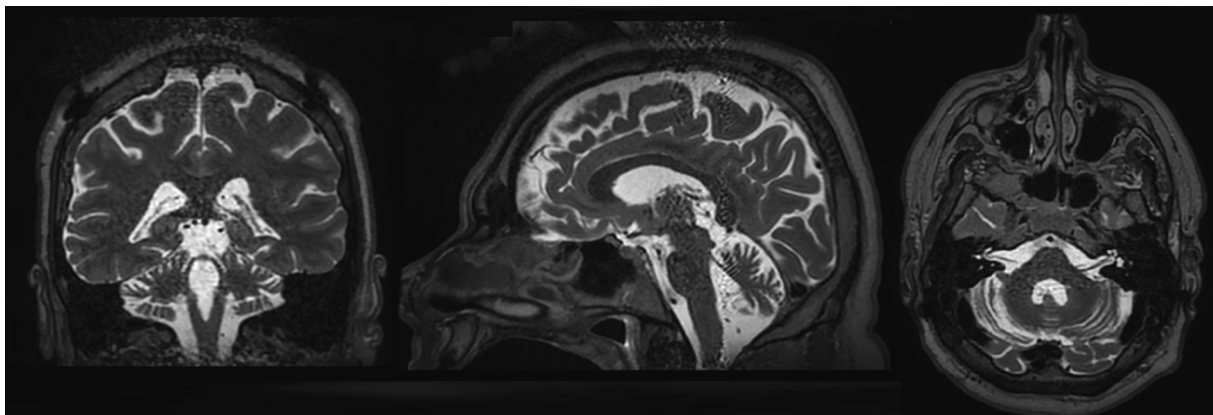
Marked cerebellar atrophy in magnetic resonance imaging T2 weighted images with enlargement of the fourth ventricle.
